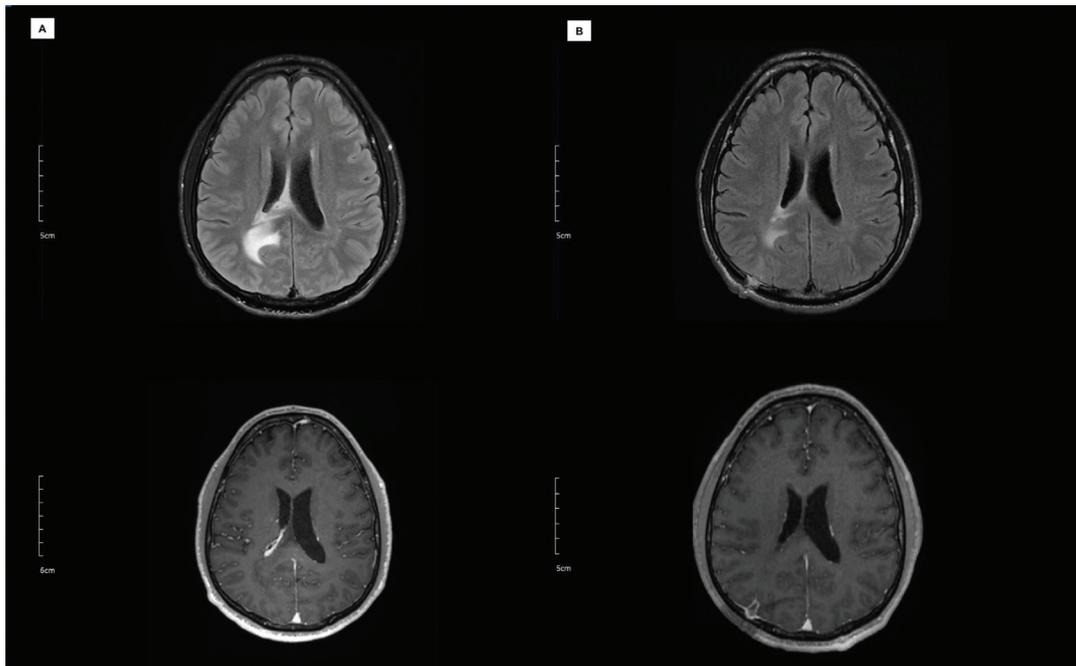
T2-weighted FLAIR and Gadolinium-enhanced T1-weighted axial views.
